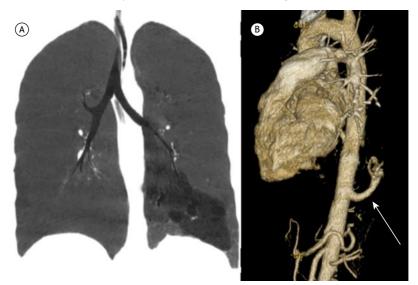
In A, computed tomography with coronal reconstruction in MINIP, evidencing a hypodense area in the lower third of the left lung lacking defined borders. In B, three-dimensional reconstruction showing the anomalous vessel emerging directly from the descending aorta (arrow).
